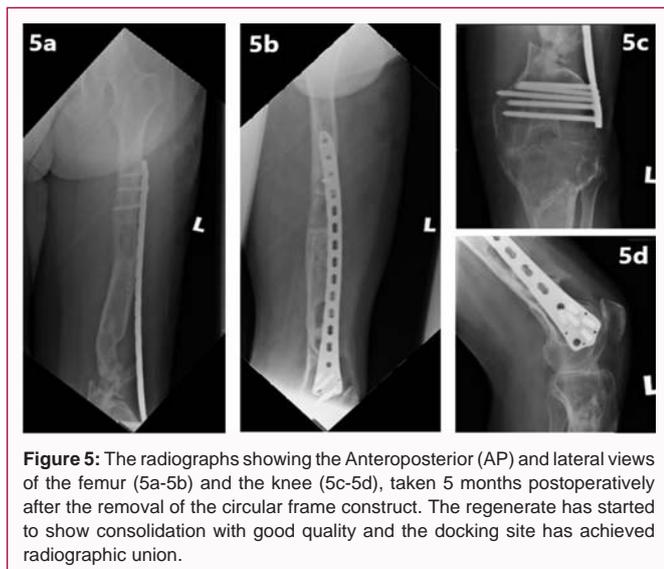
The radiographs showing the Anteroposterior (AP) and lateral views of the femur (5a-5b) and the knee (5c-5d), taken 5 months postoperatively after the removal of the circular frame construct. The regenerate has started to show consolidation with good quality and the docking site has achieved radiographic union.
